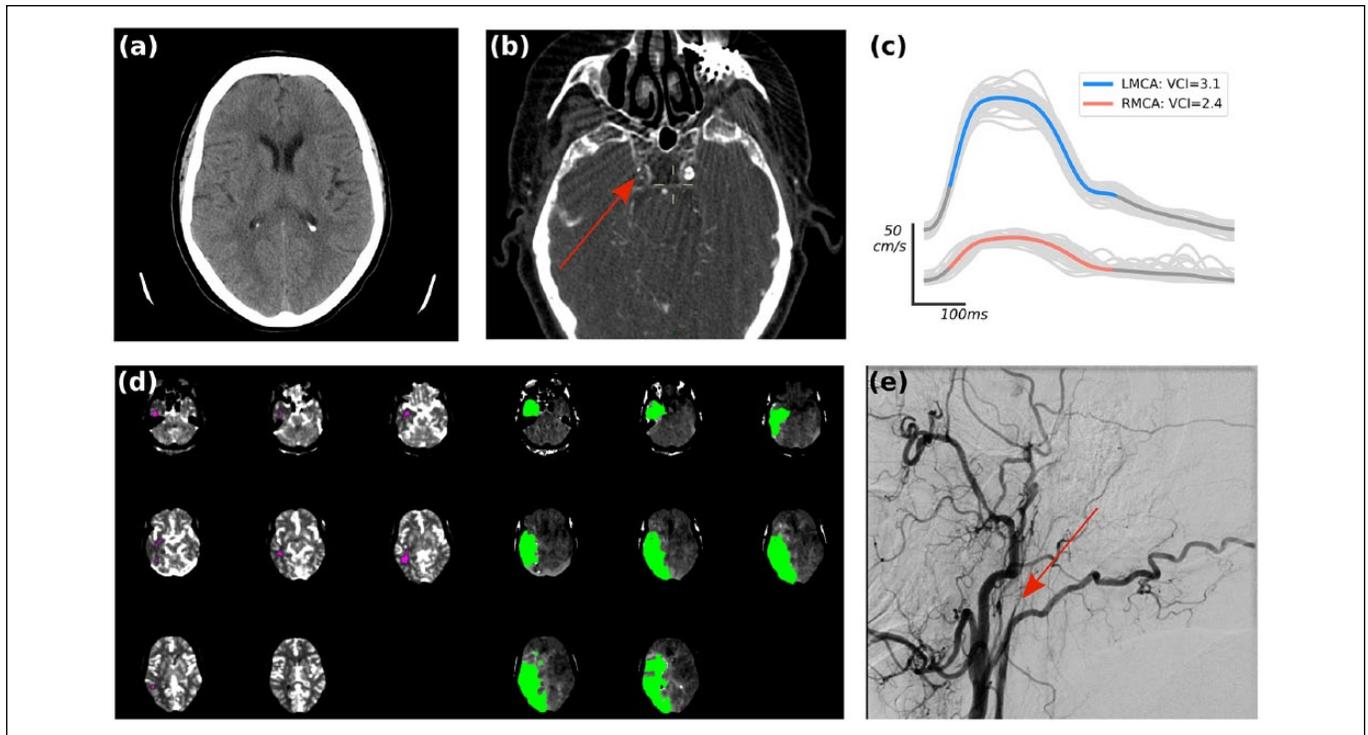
(a) Head CT only suggested a possible abnormality in the caudate region. (b) CTA revealed a severe tapering of the ICA, consistent with an occlusion. (c) Bilateral recordings of the MCA with TCD resulted in a morphological difference between hemispheres quantified by the VCI metric (3.1 LMCA, 2.4 RMCA). (d) CT perfusion imaging revealed a mismatch ratio of 39.7 between hemispheres. (e) The embolic risk was deemed too high during EVT to continue.
